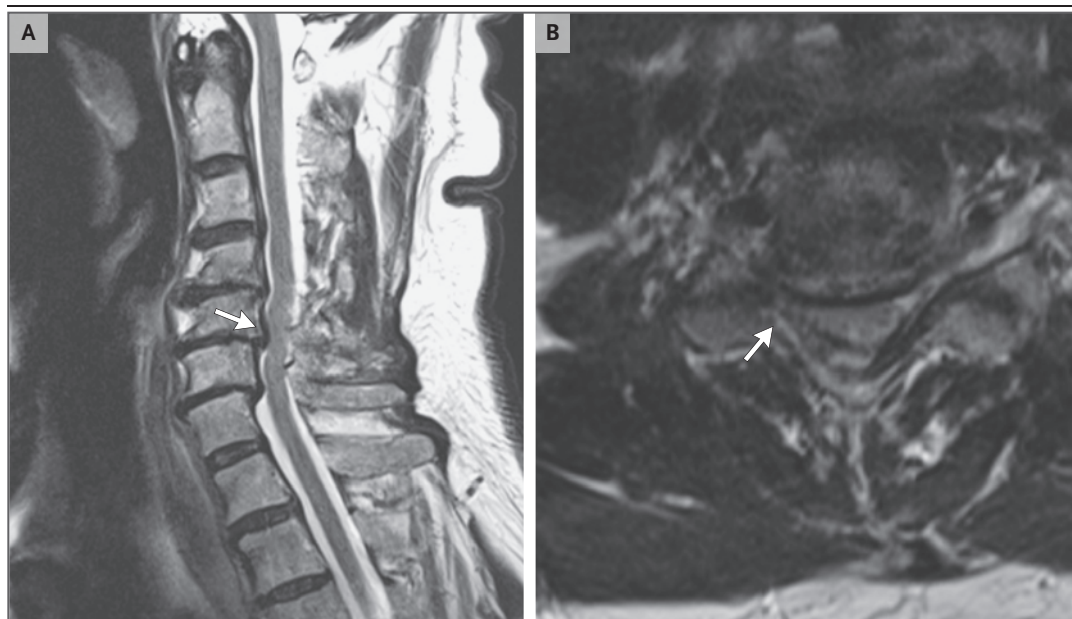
MRI Scans of the Cervical Spine in a Patient with Cervical Spondylosis.
